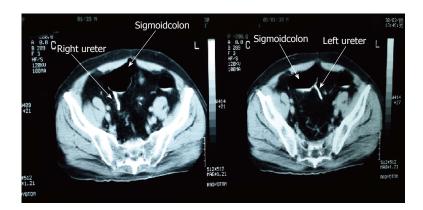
Bilateral ureterosigmoidostomy revealed by an abdominal computed tomographic scan.
